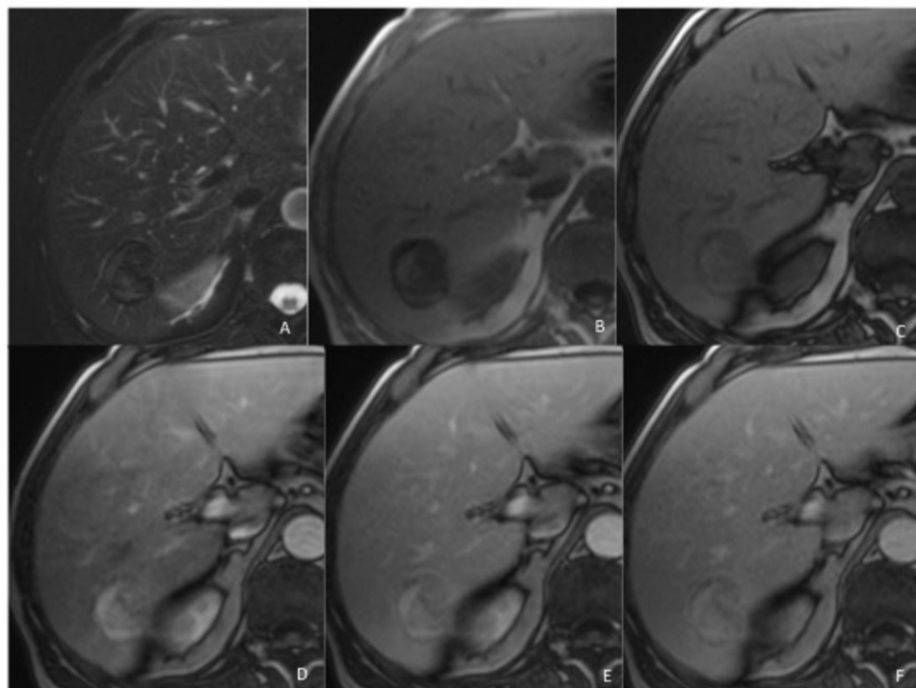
Pigmented hepatocellular adenoma. On a T2-weighted MR images the pigmented HCA shows marked hypointensity and a intralesional signal drop on in-phase (B) image compared with out-of-phase image (C), which is consistent with intralesional siderosis. Contrast-enhanced T1-weighted MR images obtained in the arterial (D) and portal venous (E) phases show the lesion with arterial phase enhancement, which persists into the portal venous phase and delayed phase (F).
